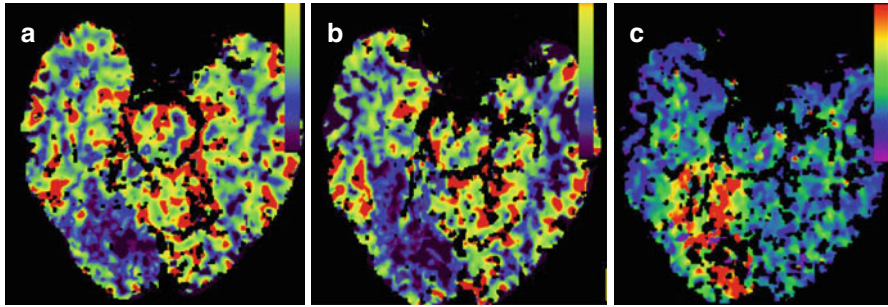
(a–c) Perfusion CT scans of hyperacute infarction in the right PCA territory. The CBV map (a) and CBF map (b) show the decrease in perfusion in the cortex and subcortical white matter of the right occipital lobe. The MTT map (c) shows the increase in perfusion in the right occipital lobe. The CBV map (a) theoretically represents the infarct core
